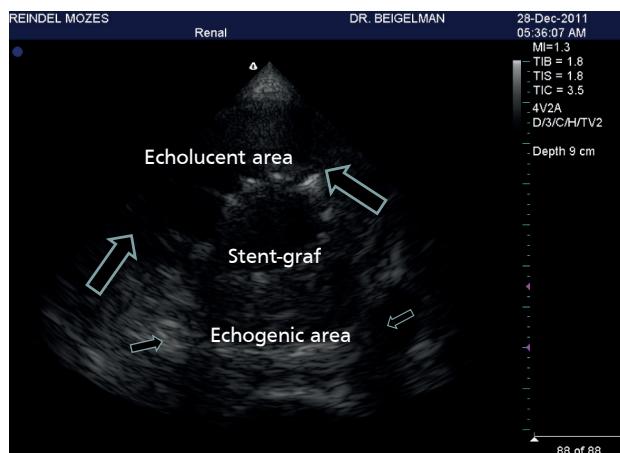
Two-dimensional ultrasound with zoom in the cross-sectional view: the ultrasonographic difference between the anterior (hemorrhagic) and posterior (thrombosed) walls of the aneurysm is clearly observed.
